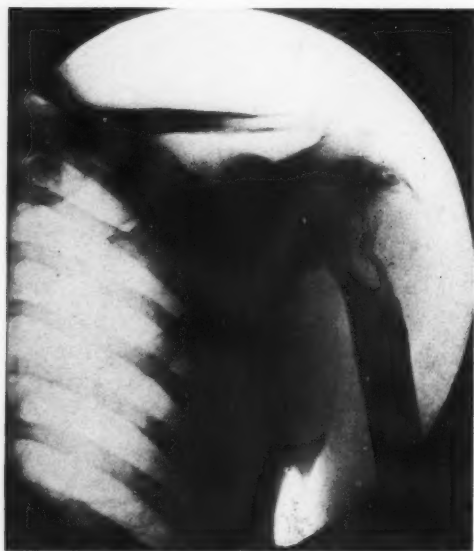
Metastatic hypernephroma. Roentgenogram shows a single destructive lesion, with absence of bone formation. The shell of the bone has been perforated and the tumor has extended into the soft parts: it has also reached the epiphysis. Path. No. 42,906.
